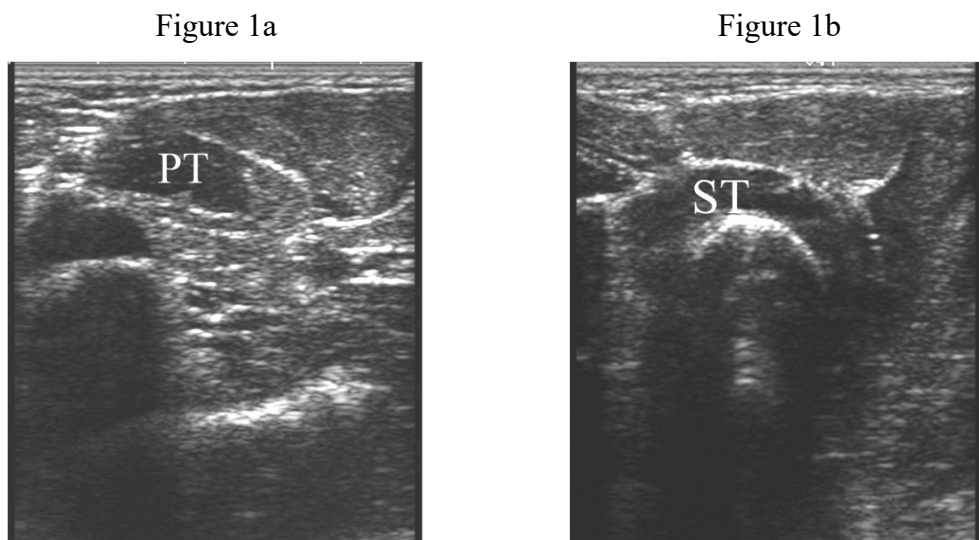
Transversal Ultrasound images showing (a) the pronator teres muscle as indicated with PT and (b) the supinator muscle as ST.
